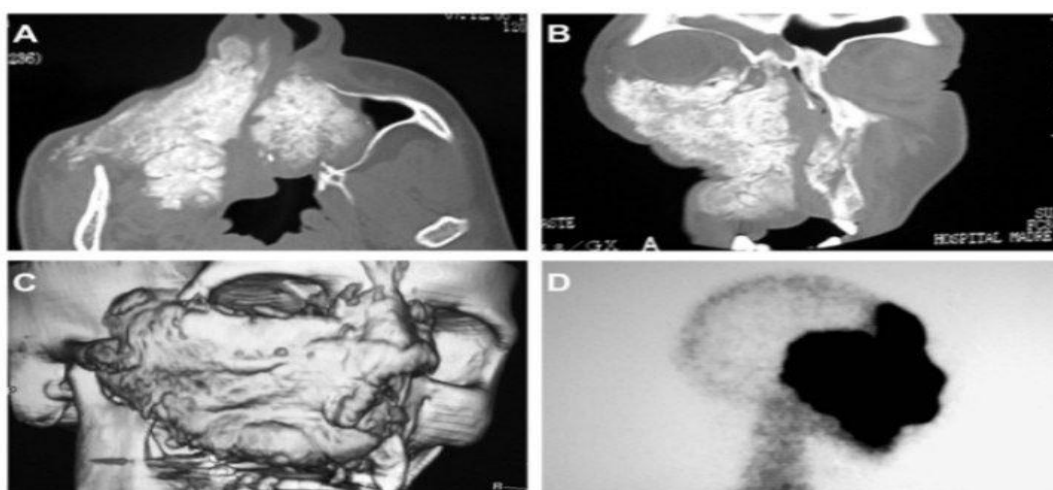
Computed tomography and bone scintigraphy. (A and B) Computed tomography demonstrating large hyperdense mass in right maxilla extending to right orbit and left maxillary sinus. (C) Three-dimensional computed tomography reconstruction showing an expansive lesion in the right hemiface. (D) Bone scintigraphy showing a hypercaptation area in the face.
